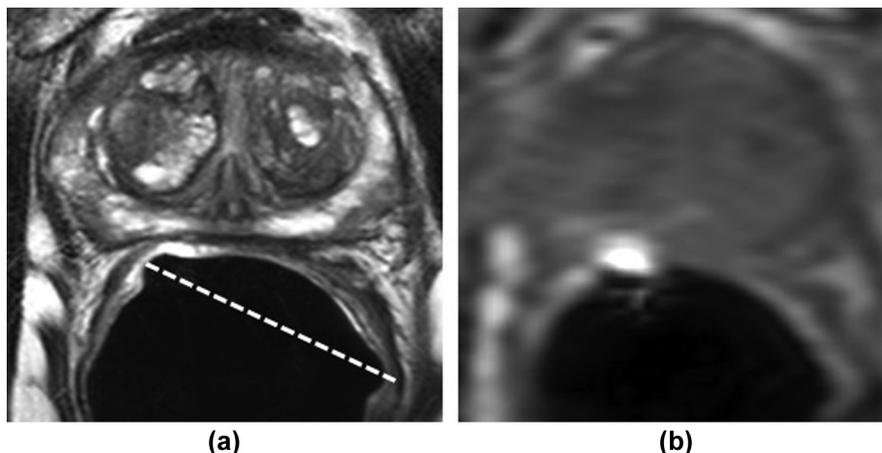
ERC incorrectly sited. (a) T2 axial image with ER coil sites; dotted line highlights coil plane. (b) Flare from the coil elements in the right mid PZ on T1-weighted imaging pre-contrast may mask enhancement or be mistaken for early enhancement if not appreciated.
